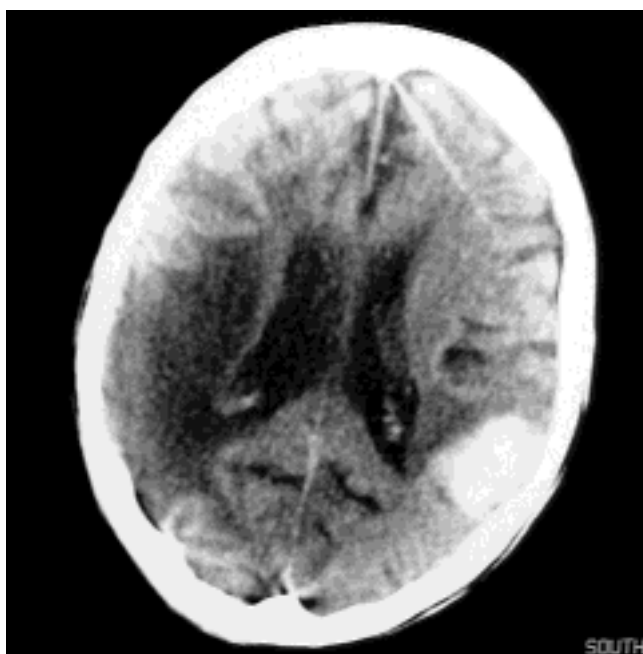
CT scan brain with haemorrhagic infarct shows as a white area in the cortex.
